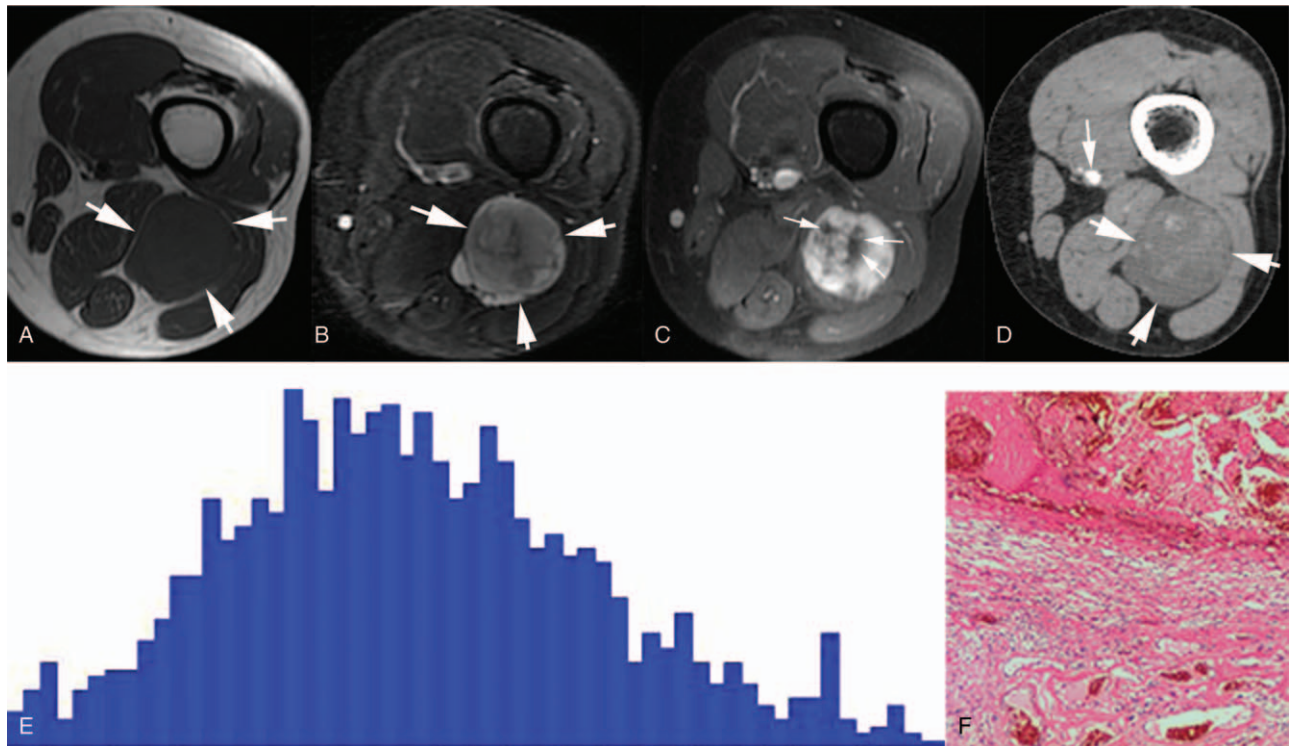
A 46-year-old woman with a left thigh mass. The tumor was isointense on T1-weighted MR (A, arrows) and hyperintense on T2-weighted MR (B, arrows). Contrast enhanced T1-weighted images depicted multiple mildly enhancing and non-enhancing lesions (C, arrows). The femoral artery was free from tumor (D, arrows). Kurtosis, skewness, and inhomogeneity derived from the histogram (E) were 0.31, 0.29, and 0.28, respectively. The pathology showed a hemangioma (F).
